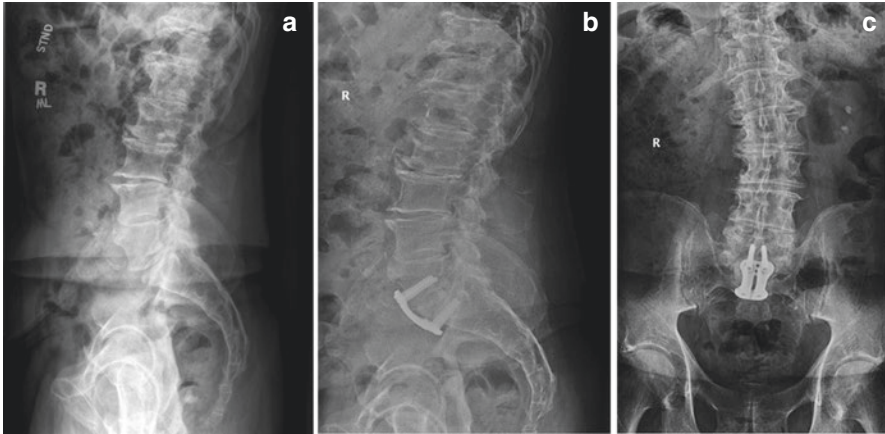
A 69-year-old male presenting for right low back and lower extremity pain. Preoperative X-rays (a) showed degenerative disk disease at all of the lumbar interspaces with associated hypertrophic changes and facet arthropathy and low-grade retrolisthesis. Postoperative X-rays (lateral (b) and AP (c)) following ALIF showed stable L5-S1 fusion with reduction of the slippage
